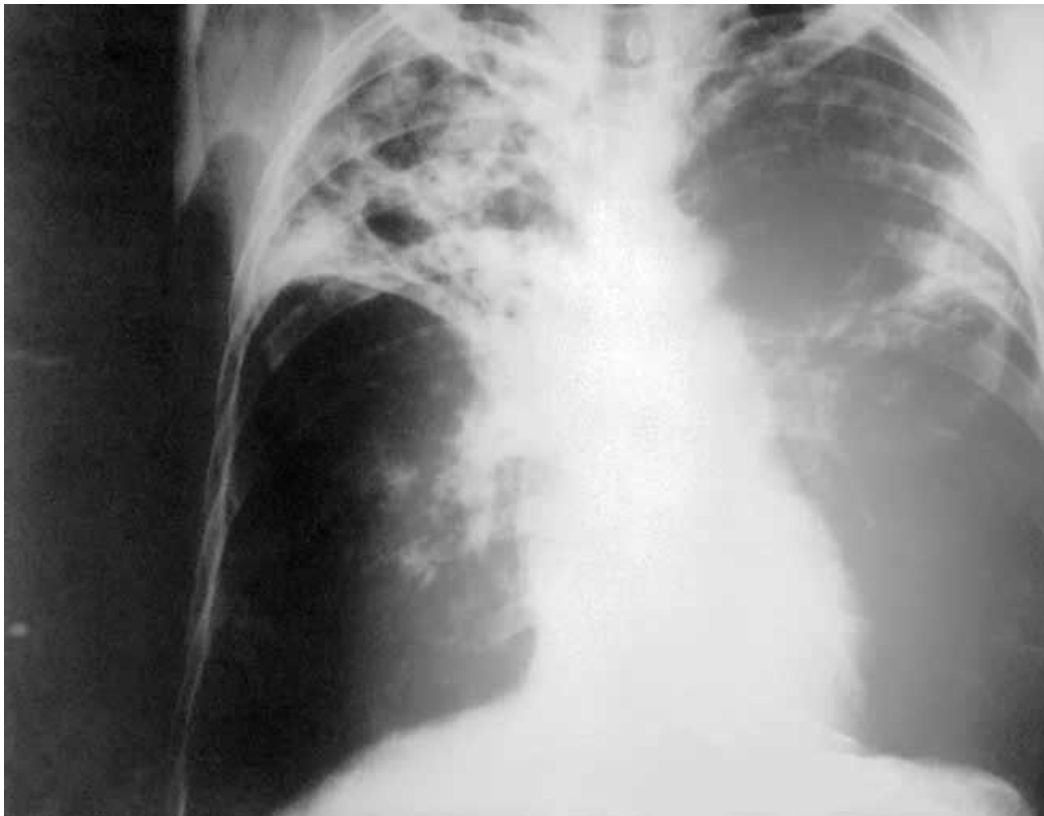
An anteroposterior X-ray of a patient diagnosed with advanced bilateral pulmonary TB. MDRTB cannot be diagnosed by X-ray alone.
